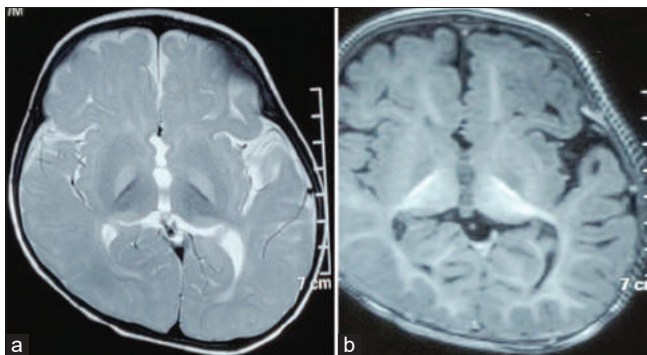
Neuroimaging of the index child. (a) T2-weighted image showing bilateral symmetrical globus pallidus hyperintensity (b) T1-weighted image showing bilateral globus pallidus hypointensity.
